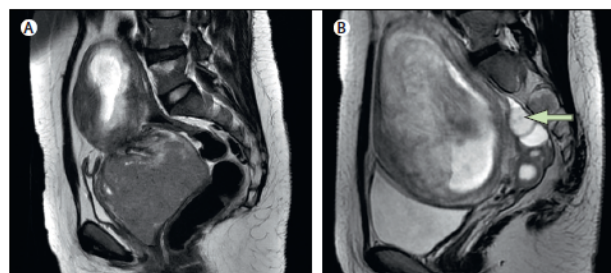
Pelvic MRI in pregnant patients
